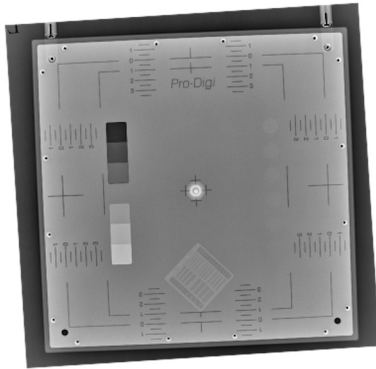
Image quality of x-ray machine using Pro-Digi, Raysafe.
